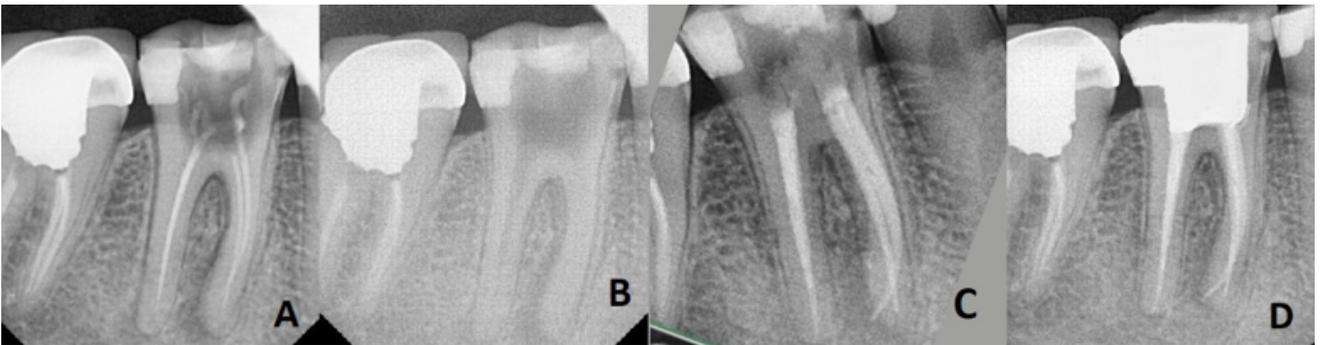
Case 2: A): Preoperative radiographic image; B): Removal of gutta percha from canals; C): Postoperative radiograph; D): 6 months follow up radiograph
